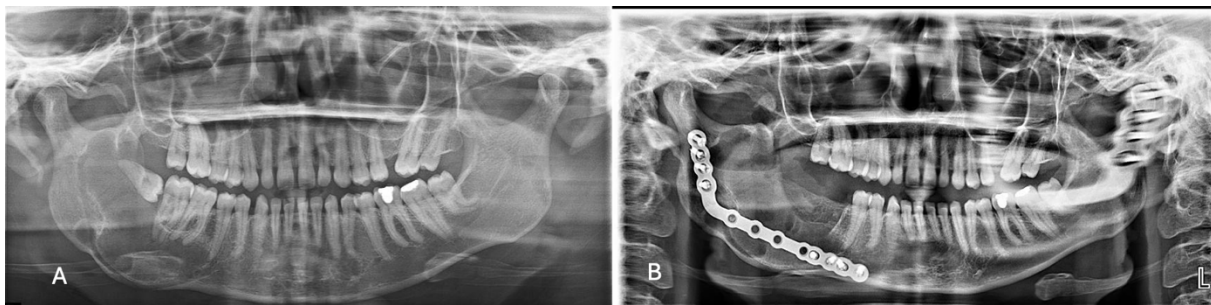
(A) Large lesion located in the mandibular angle region. (B) Postoperative radiograph following surgical management and reconstruction plate fixation.
